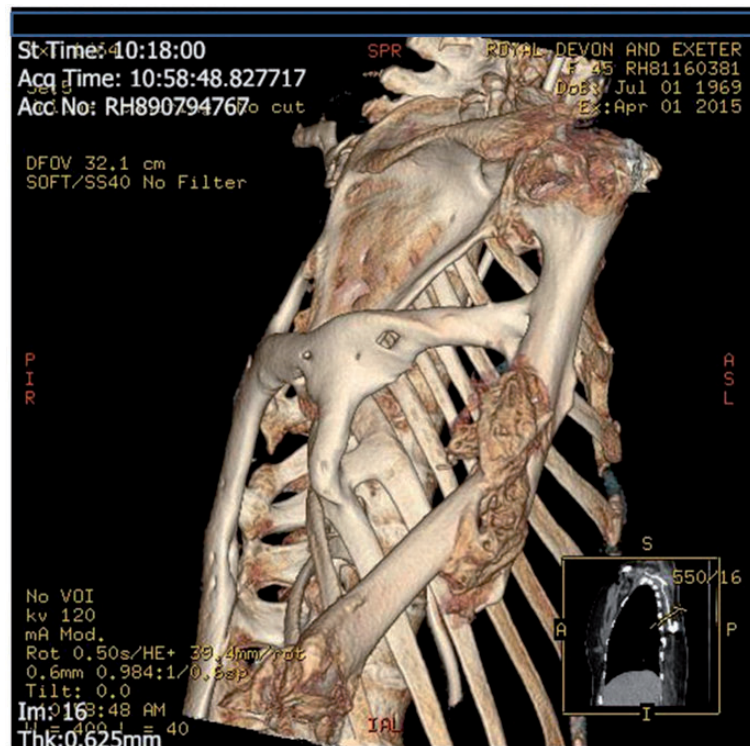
Three-dimensional CT reconstruction showing humeral fracture and pre-existing bony fusion mass from thoracic spine, scapula and ribs to humerus.
